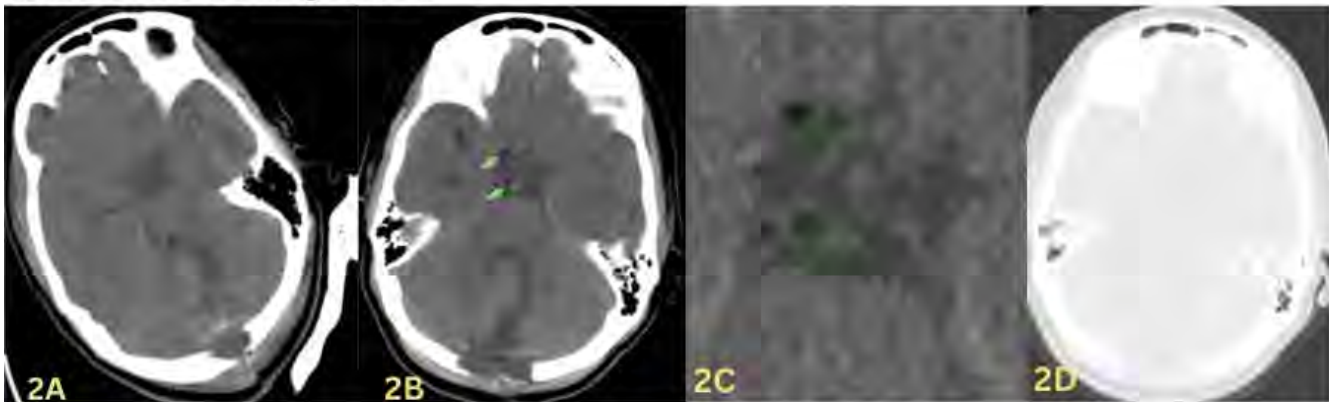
A) Axial noncontrast CT head obtained prior to lumbar drain placement demonstrates expected postsurgical changes from suboccipital craniectomy for left cerebellar mass resection, without low-attenuation foci along the basal cisterns, serving as the pre-lumbar drain baseline. B) Axial noncontrast CT head, windowed to accentuate fat density, obtained four days following lumbar drain placement shows new low-attenuation foci along the subarachnoid spaces and basal cisterns, consistent with fat density (green arrows). C). Magnified axial CT images from same acquisition highlight low-attenuation foci along the basal cisterns. Measured attenuation values (-38 to -25 HU) confirm the presence of fat density, consistent with subarachnoid fat deposits. D) Axial CT head, lung window, at the same level shows no intracranial air, effectively excluding pneumocephalus and suggesting that the low-attenuation foci may represent fat emboli within the subarachnoid space.
